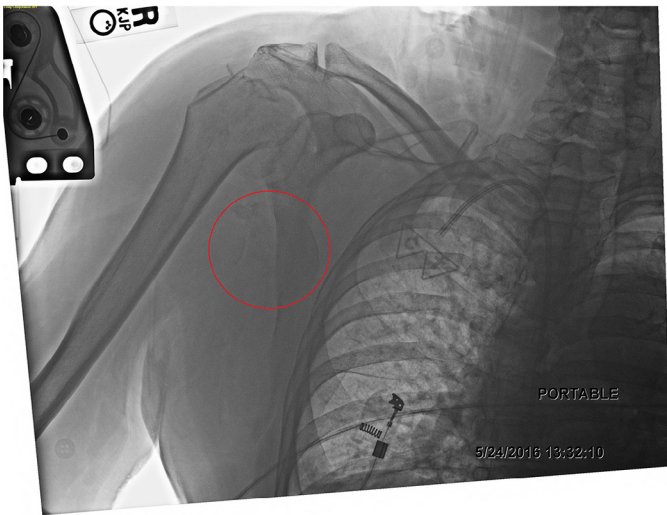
Initial portable anteroposterior x-ray image reveals humeral head displacement.
